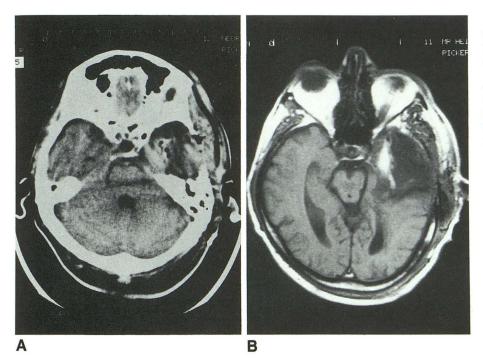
Axial unenhanced CT image (A) and axial T1-weighted (600/20/2) unenhanced MR (B) obtained on first day after extirpation of a glioblastoma.
